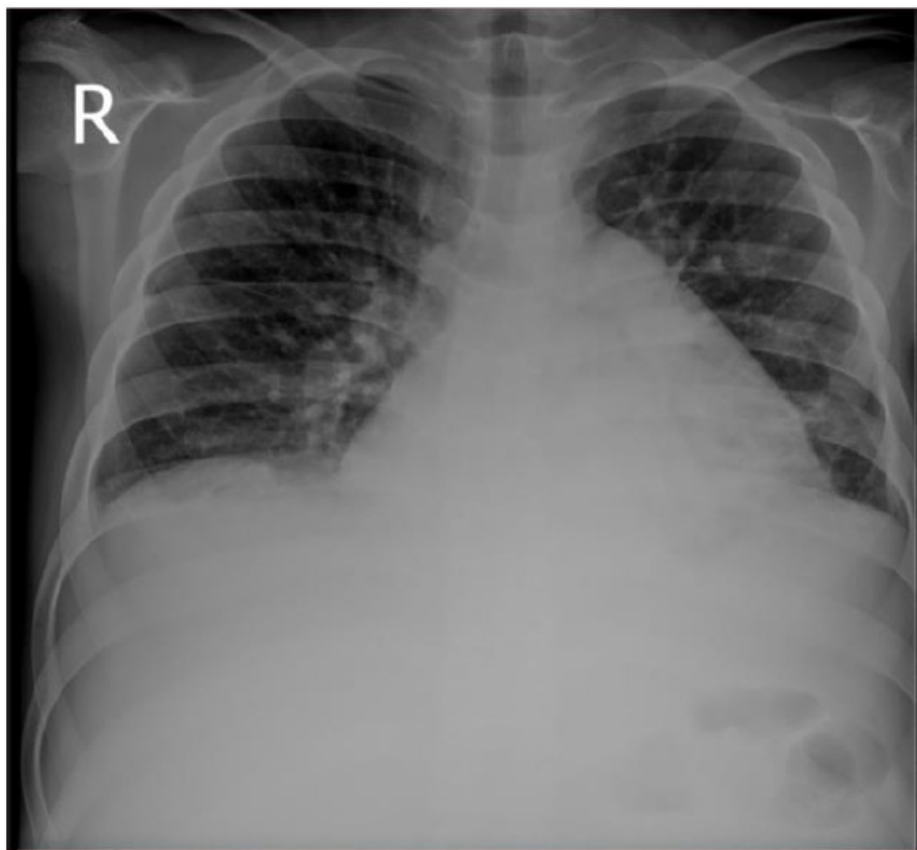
Chest X-ray of patient 1
